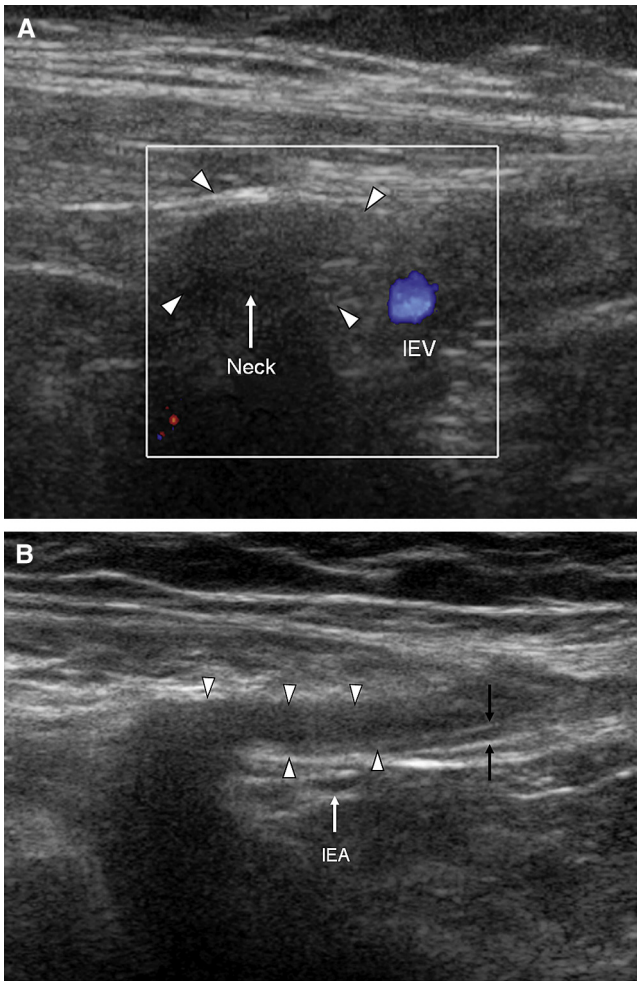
(A) Right indirect inguinal hernia; transverse sonogram of the right inguinal region, showing the neck (arrow) of the hernia (arrowheads) lying lateral to the inferior epigastric vessels (IEV) compatible with an indirect inguinal hernia. (B) Indirect inguinal hernia; oblique sonogram of the same patient in Figure 4A delineates the hernia sac (white arrowheads) of the indirect inguinal hernia inside the inguinal canal; the hernia originates from the deep inguinal ring lateral to the inferior epigastric artery (IEA, white arrow) and crosses superficial to it and extends along the inguinal canal; the hernia sac passes anterior to the spermatic cord (black arrows). The sac mainly contains fluid. This figure is available in colour online at <http://carjonline.org/>.
